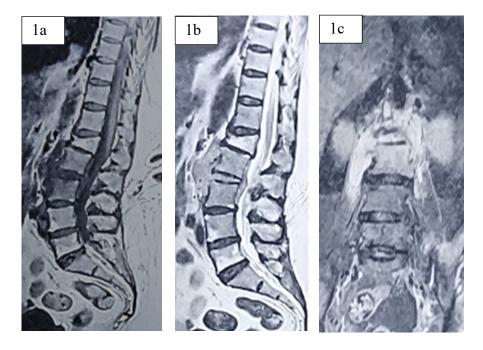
(1a) MRI T1-weighted image with increased prevertebral soft tissue enhancement extending into the anterior epidural space at L2-L3. (1b) T2-weighted image demonstrating increased signal at L2-L3 disc space with small epidural abscess associated vertebral body edema compatible with acute discitis and osteomyelitis. (1c) Coronal image with bilateral psoas abscess more on the right side.
